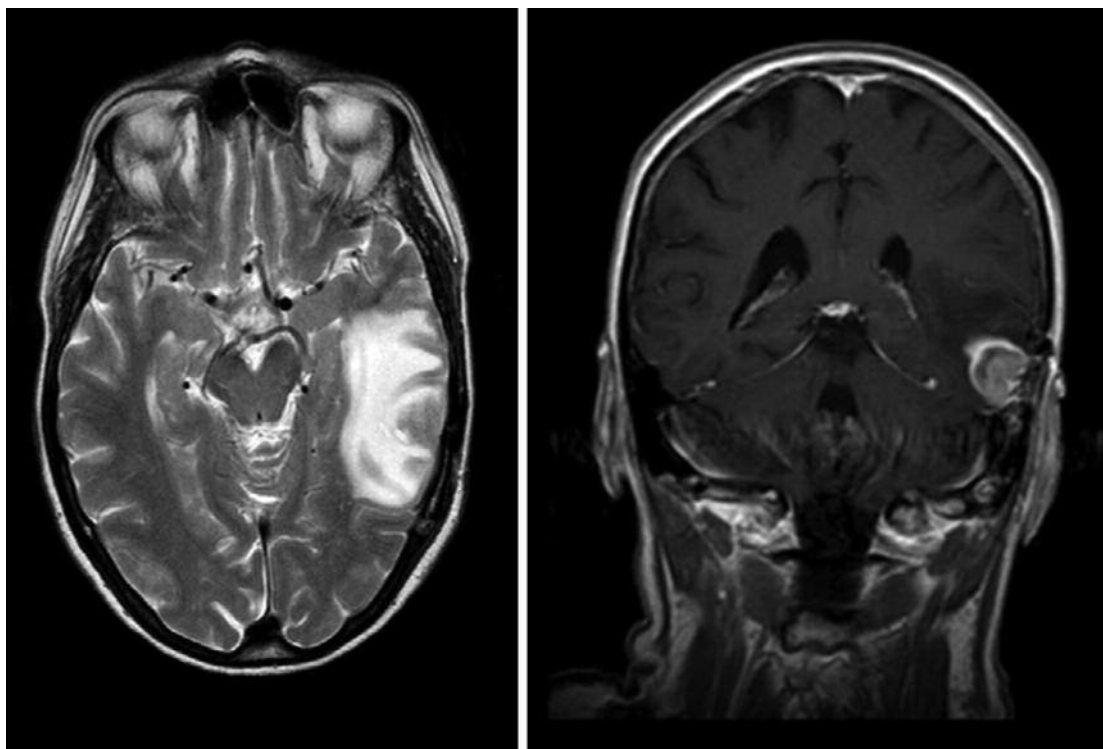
MRI scans revealed a recurrent lesion in the resection cavity on the left temporal side on transversal (left) and frontal (right) sections.
